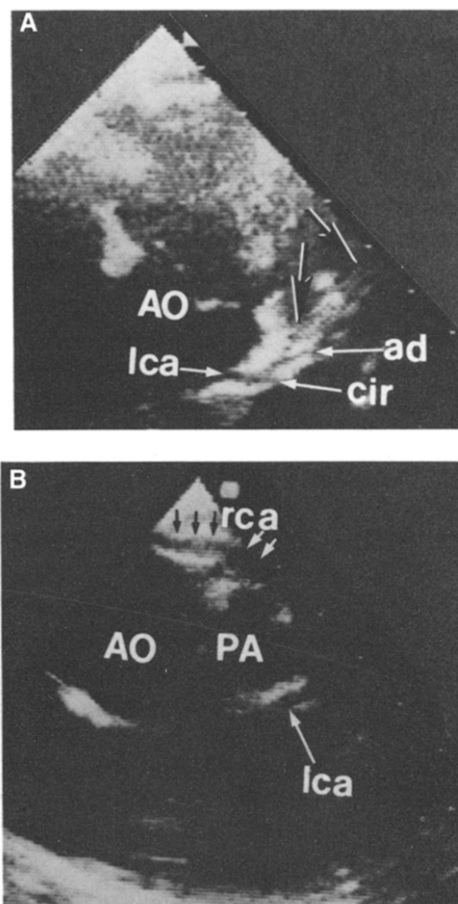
A, Apical five chamber view from a patient with origin of both right and left coronary arteries from a single left ostium. There is one left coronary artery (lca) that divides into three equal-sized branches. Unlabeled black arrowheads point toward the right coronary artery as it originates from the left coronary artery and to its course anteriorly. B, Modified left parasternal view from the same patient, demonstrating the course of the right coronary artery (rca) (arrows) in front of the right ventricular outflow tract (see also Fig. 8). Abbreviations as in Figure 1.
